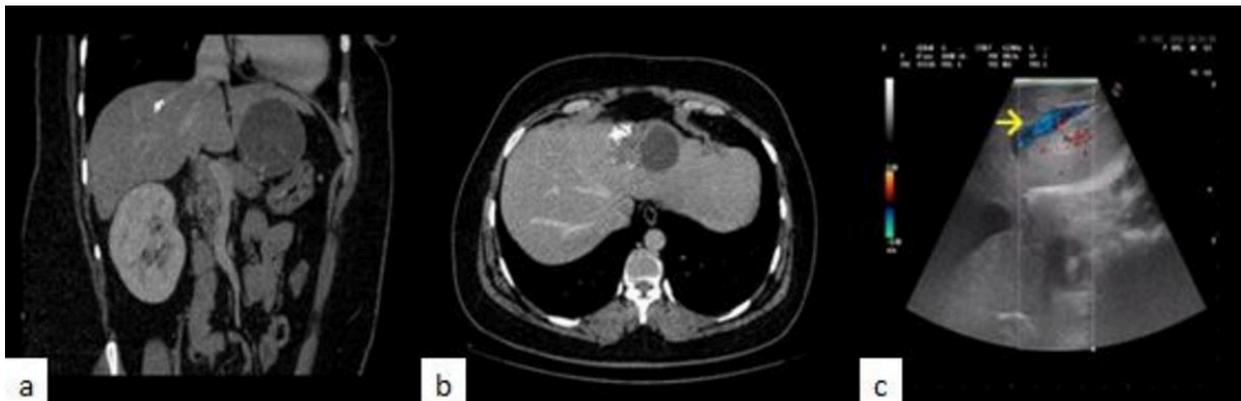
a-b:CT-scan coronal and axial images showing a hydatid cyst of the left liver. Left hepatic vein has not been visualized. c : IOUS was performed after evacuating the content of the cyst and showed a permeable left hepatic vein.
